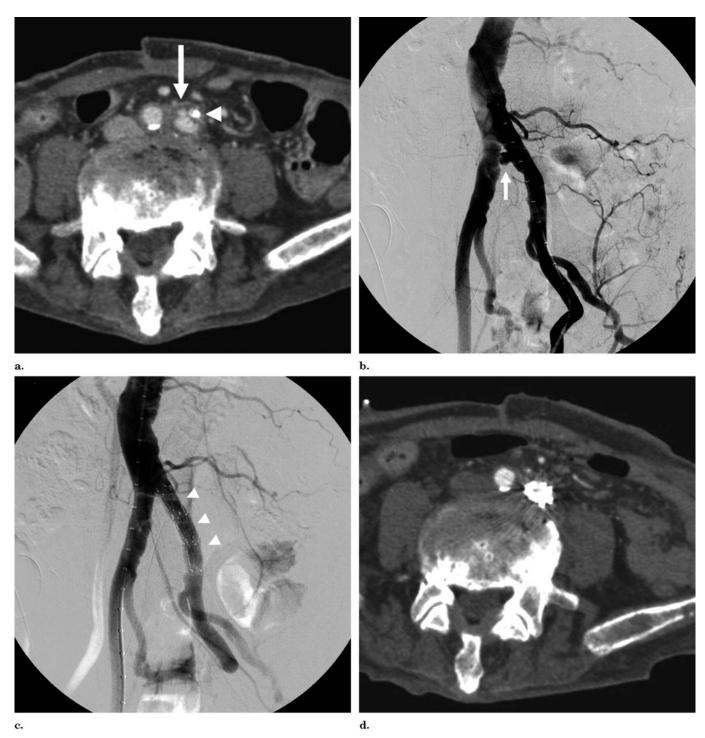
(a) CT shows a left common iliac artery pseudoaneurysm (arrow) near the ureteral stent (arrowhead). (b) Preprocedural angiography shows an pseudoaneurysm (arrow) originating from the left common iliac artery. (c) Immediately after stent-graft placement (arrowheads), complete exclusion of the pseudoaneurysm is confirmed. (d) Contrast medium–enhanced CT 8 days later shows no evidence of contrast material extravasation.
